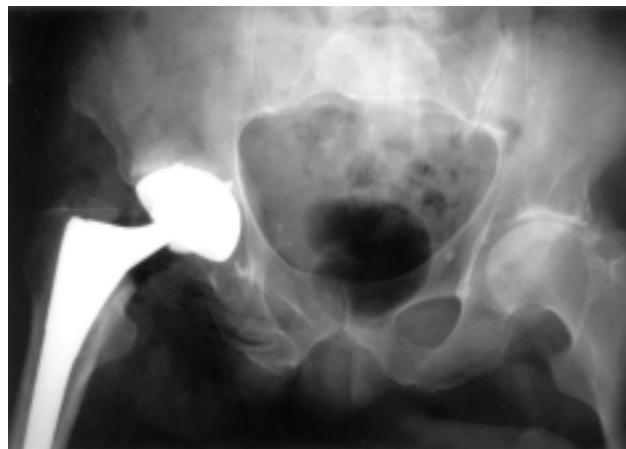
Postoperative radiograph of an MITHR.
